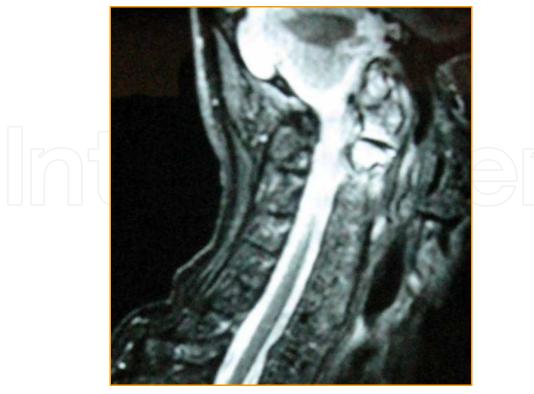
MRI of the same patient with a fracture of the axis.
